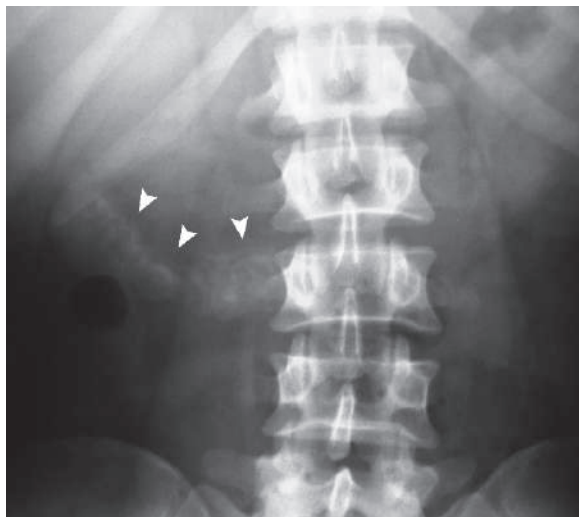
Plain abdominal radiograph shows calcification of the transverse colon walls in a patient with schistosomiasis (arrowheads)
